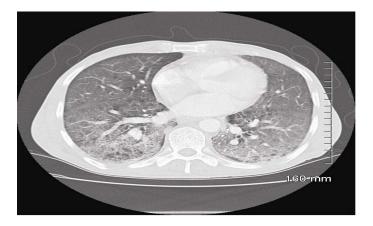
CT-scan of the same patient.
